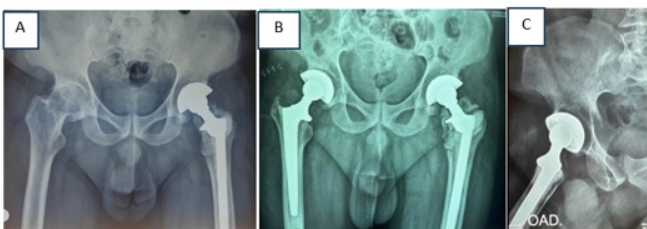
Preoperative radiographs of the right total hip replacement (A). Postoperative radiographs show protrusion of the superolateral acetabular region (B) and (C).
